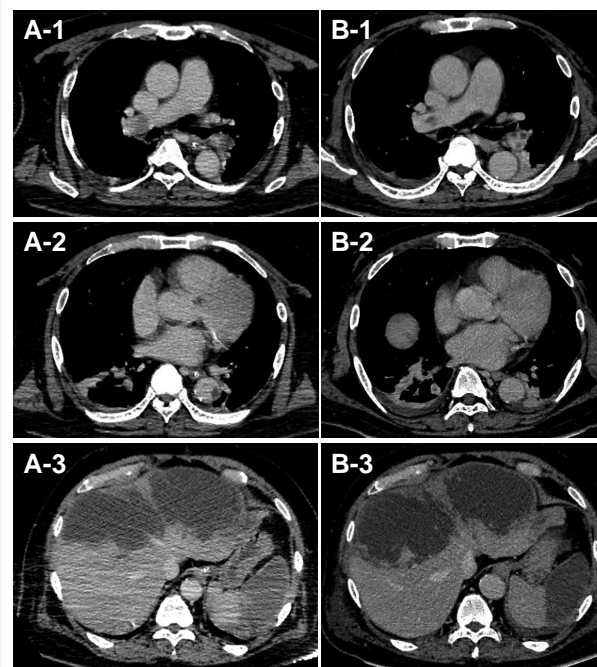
(A) Contrast-enhanced computed tomography on Day 9 showed an exacerbation of the systemic thrombotic embolisms. (B) Fourteen days after prescribing anticoagulants, contrast-enhanced computed tomography showed that the thrombi had decreased.
